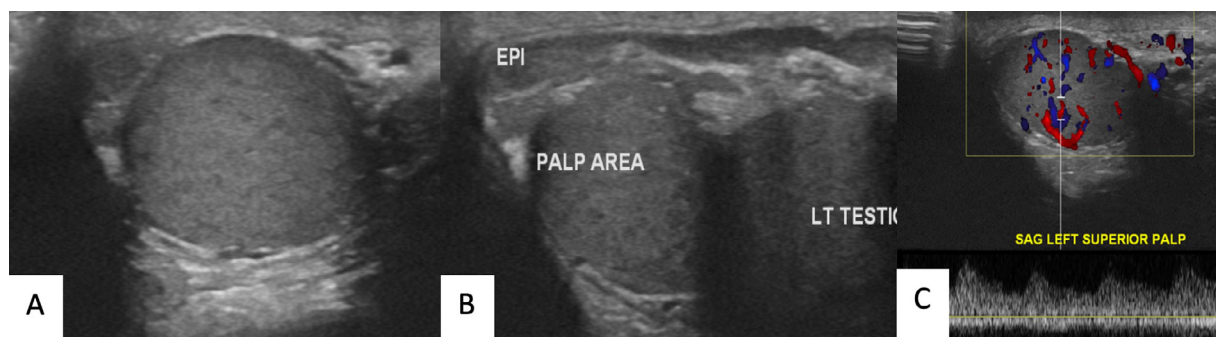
(A) Sonographic evaluation of the left hemiscrotum demonstrates a hypoechoic well circumscribed lesion. (B) Sonographic evaluation demonstrating lesion between left epididymis and left testis abutting the testicle. (C) Color doppler evaluation demonstrates venous and arterial blood flow with the lesion.
